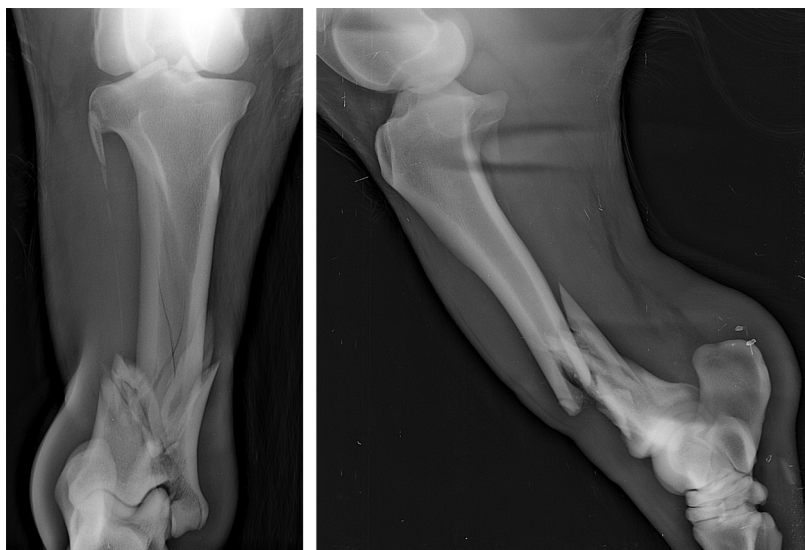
Radiographic examination 1 day after the accident. Dorsoplantar (left) and lateromedial (right) radiographic views are shown. A comminuted fracture of the diaphysis of the tibia is clearly visible; the distal metaphysis is also involved, with the medial malleolus displaced distally, affecting the tibiotarsal joint. Spiral lines are also present from the comminution site and up to the proximal third of the diaphysis.
